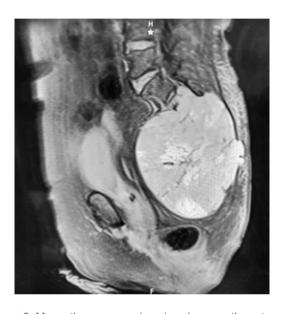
Magnetic resonance imaging shows us the extension of a neoplasia both intra and extracompartmentally.
